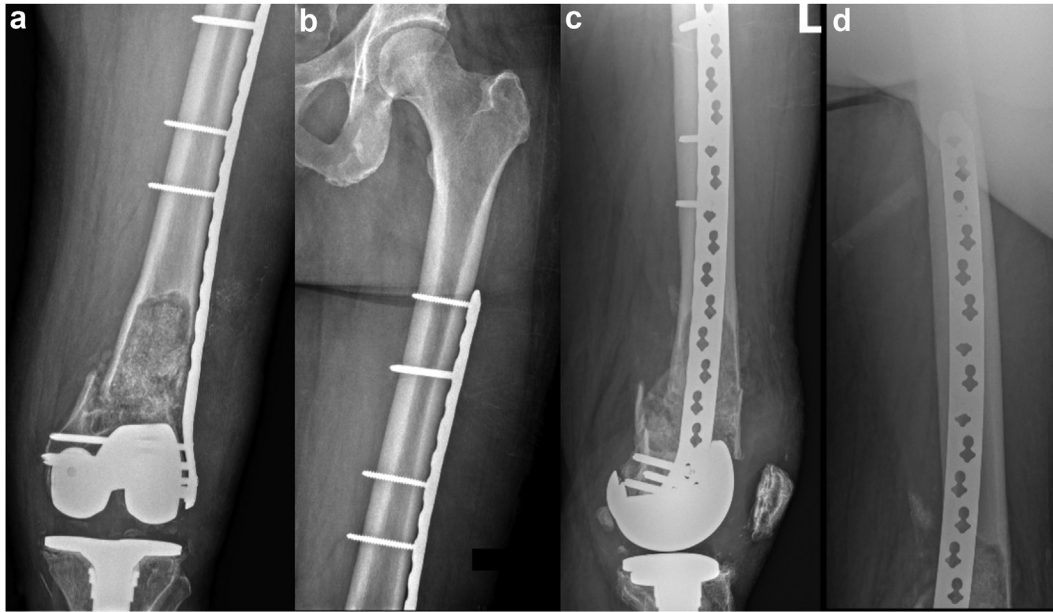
(a and b) AP and (c and d) lateral, immediate postoperative radiographs of the left femur demonstrating fracture fixation with lateral plating and allograft augmentation of the osteolytic lesion. Of note, the plate was placed more posteriorly within the distal segment of the fracture to attempt to achieve a better fixation in the limited bone stock remaining, which was quite poor directly behind the femoral flange.
